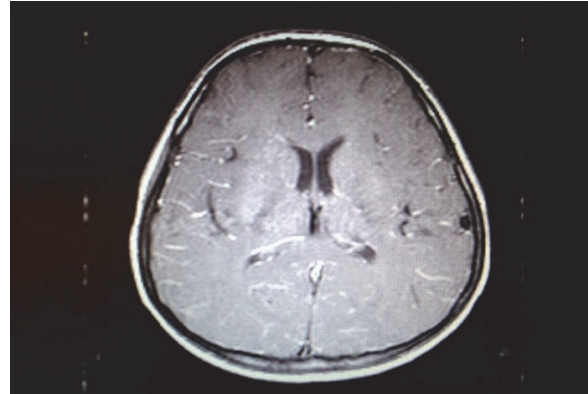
Increased contrast in the meningeal areas and suppression in neighboring sulcal areas in brain CT.
